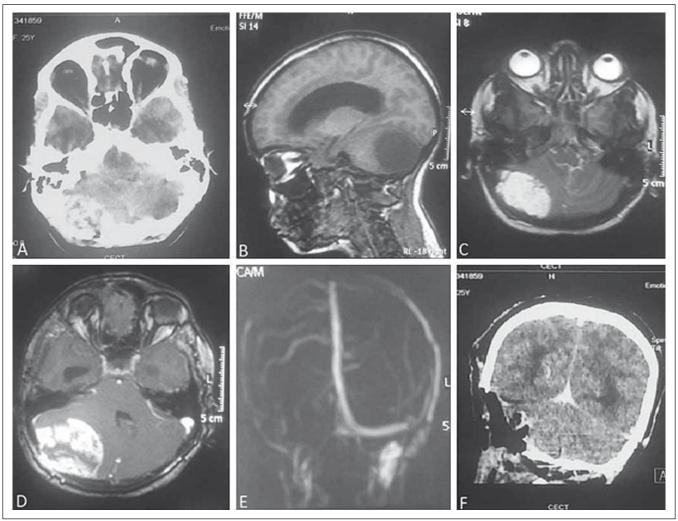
Contrast-enhanced computed tomography (CECT) of the brain showing heterogeneously contrast-enhancing lesion at the right posterior fossa with erosion of the overlying bone (A). On MRI, the lesion is isointense on T1 (B) and hyperintense on T2-weighted image (C) with intensive post-contrast enhancement (D). There is non-visualization of the right transverse sinus (E) on MRA. Figure F is post-operative CECT of the brain showing complete removal of the lesion.
